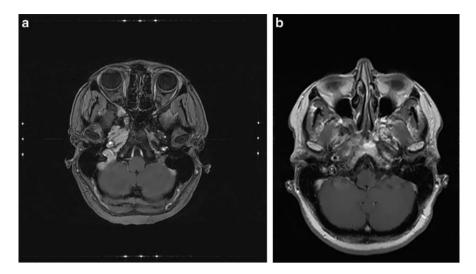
Axial MRI scan of a patient with adenoid cystic carcinoma (ACC) of the skull base (a) prior to IBT, (b) 6 months after treatment
